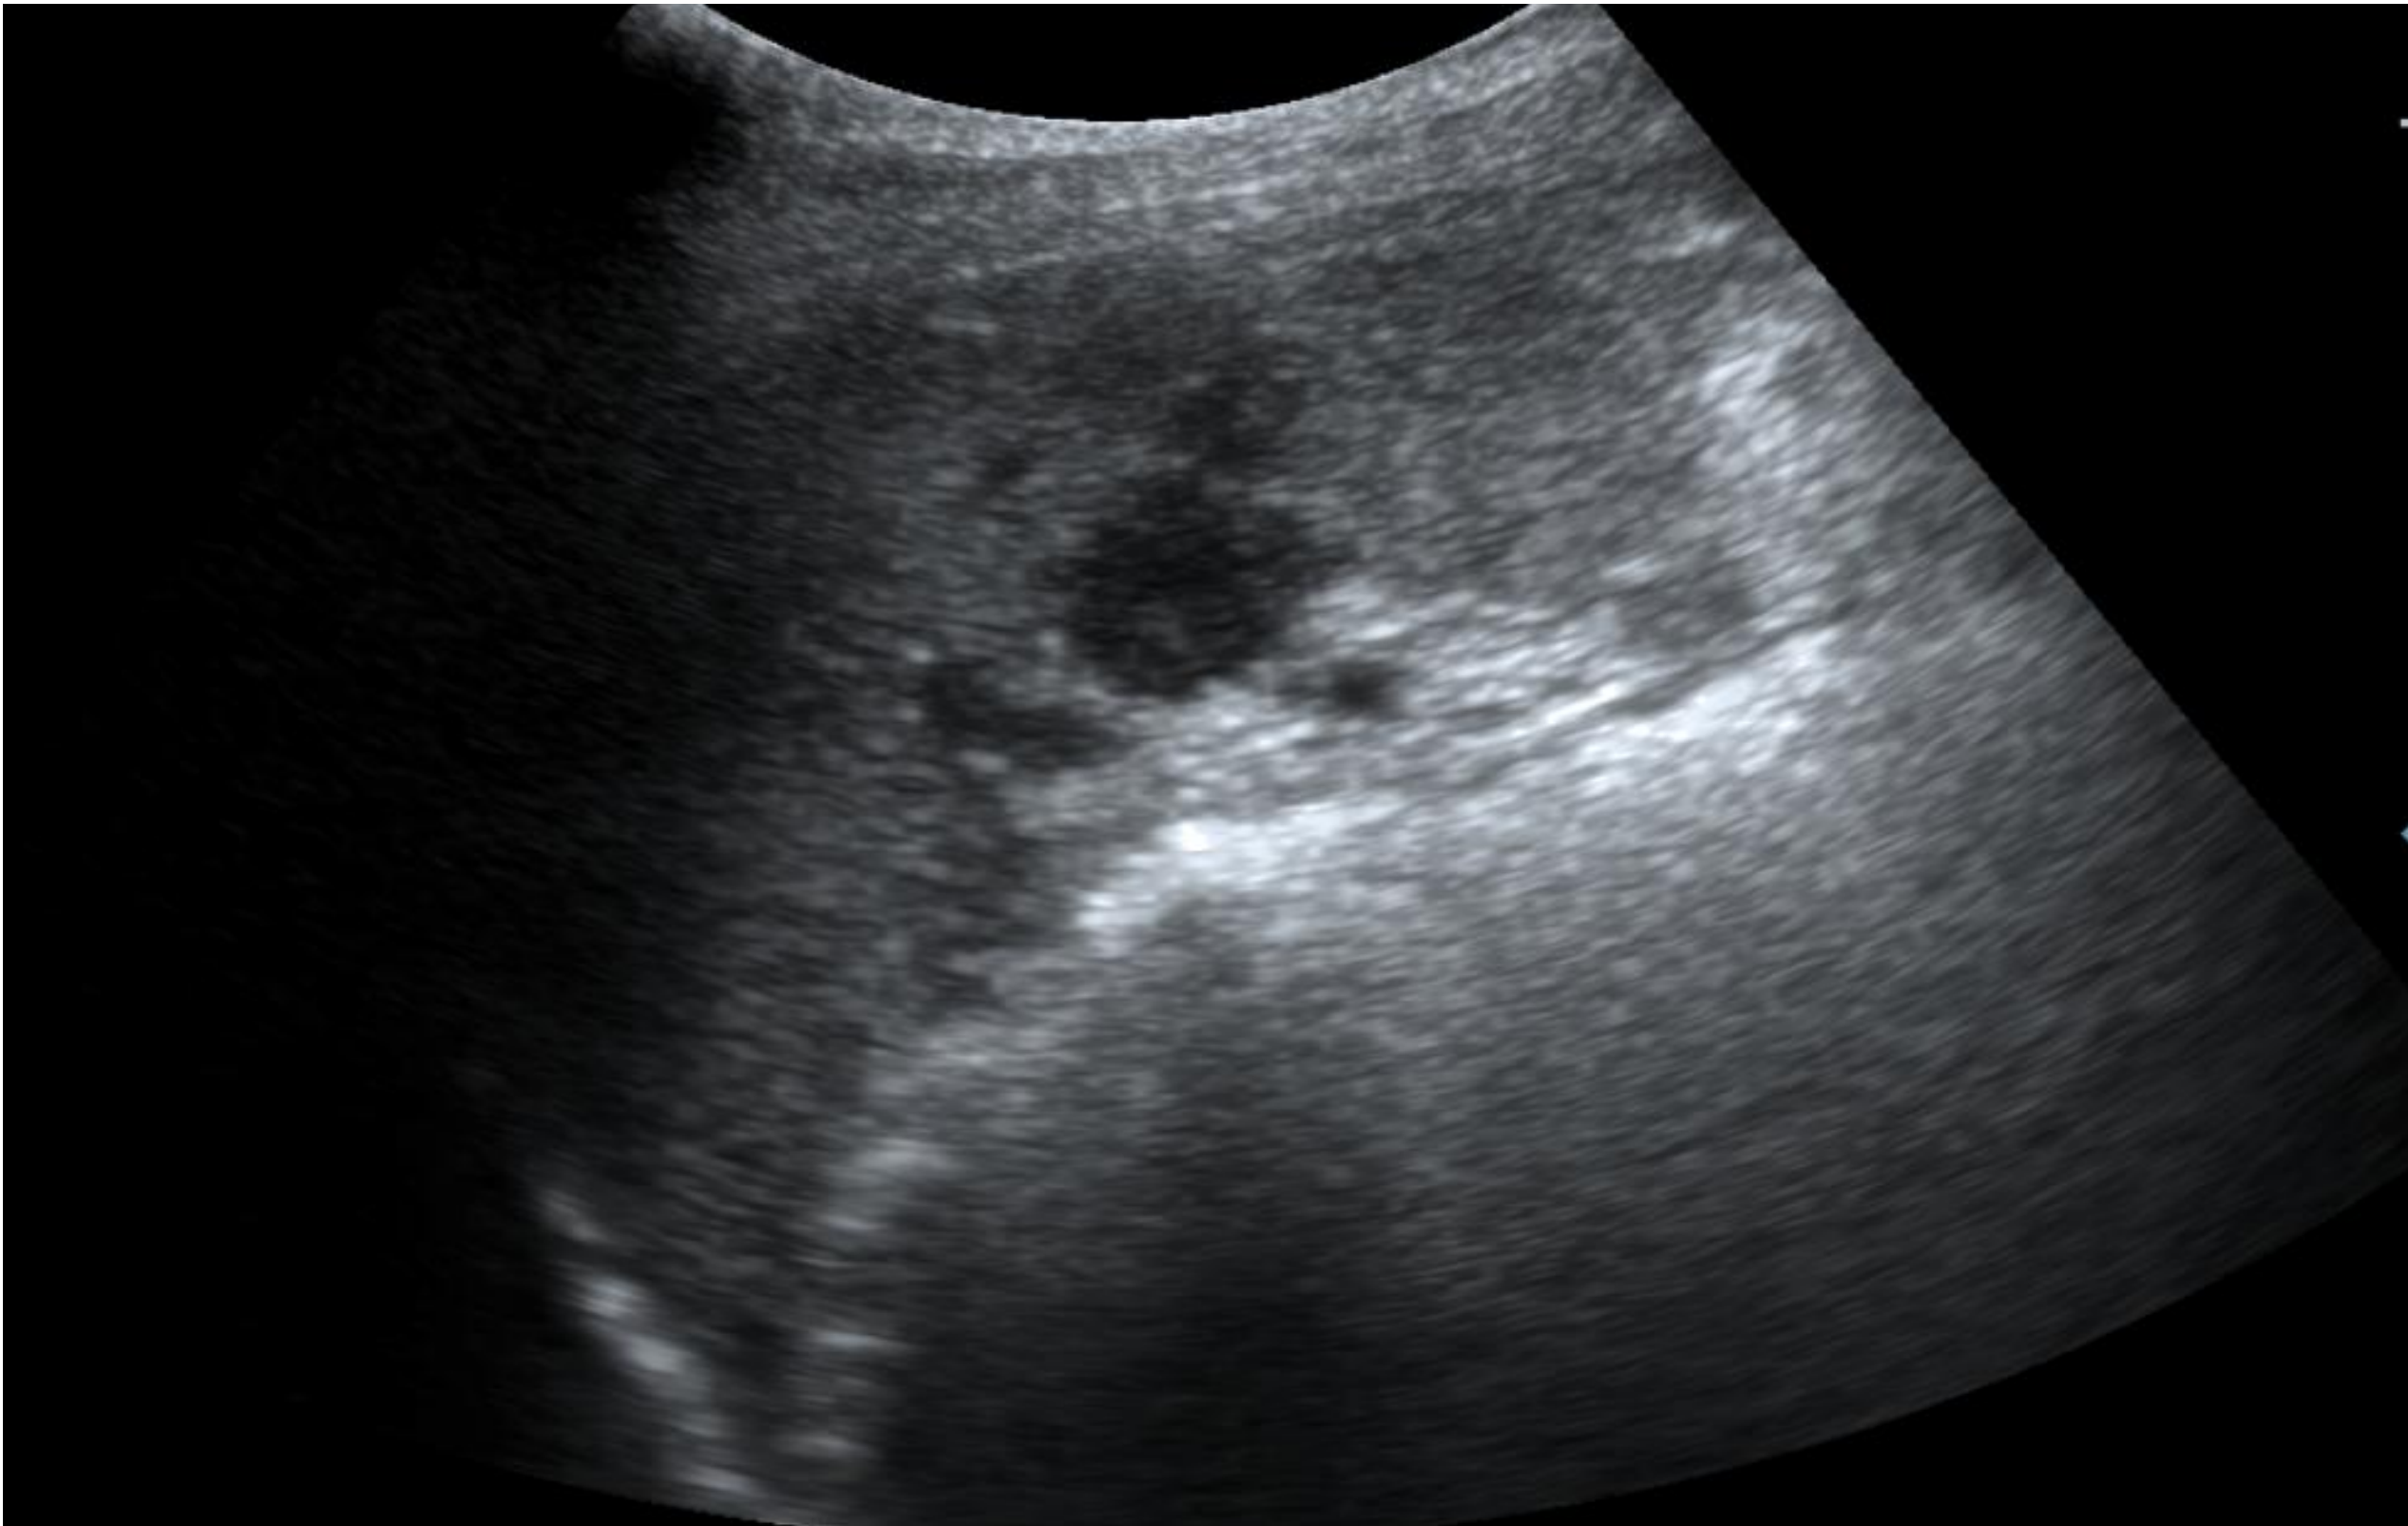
Follow-up ultrasound (2 months after the injury): no hemoperitoneum, organizing hematomas, no pseudoaneurysm.
